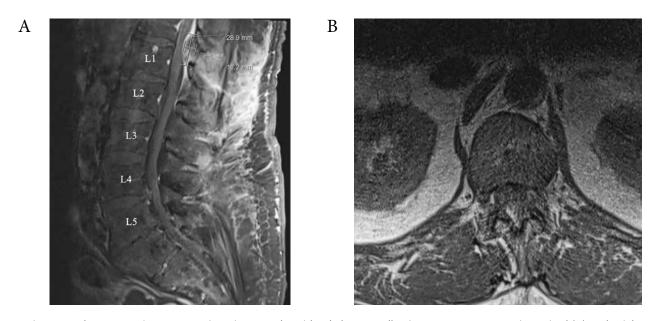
Lumbar magnetic resonance imaging reveals epidural abscess collection at T12-L1 as seen in sagittal (A) and axial (B) views.
